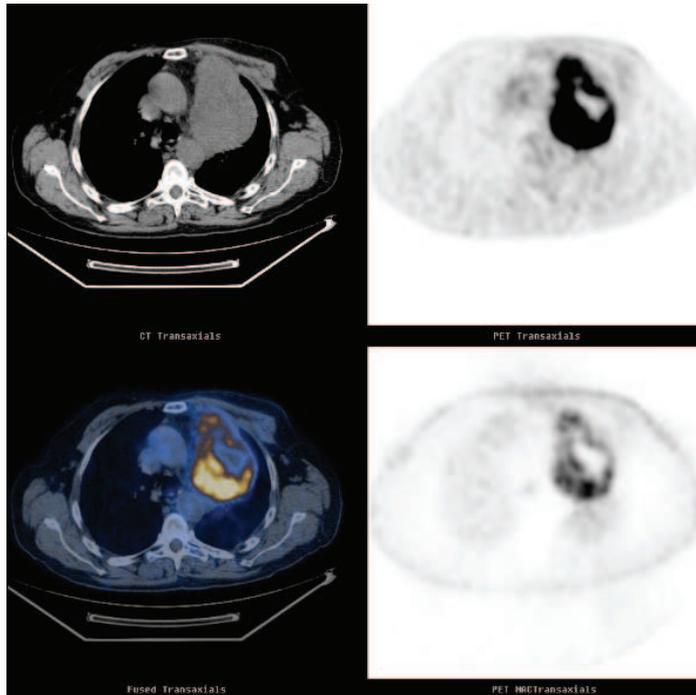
Fused PET-CT image of a lung cancer.
